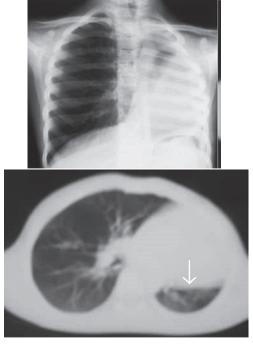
a) X-ray chest: Left pulmonary hypoplasia. b) CT chest: pulmonary hypoplasia (left).
